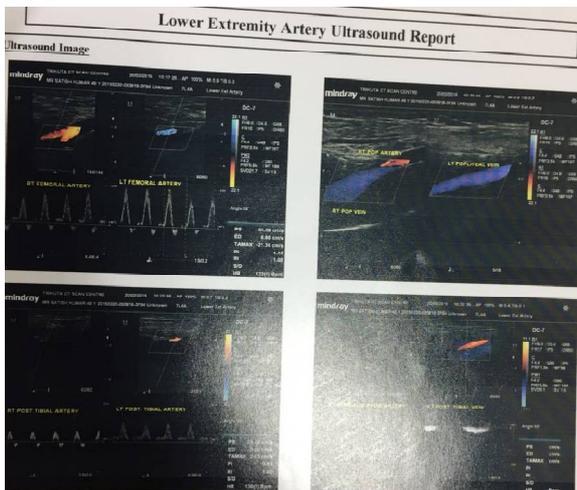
Doppler characteristics
